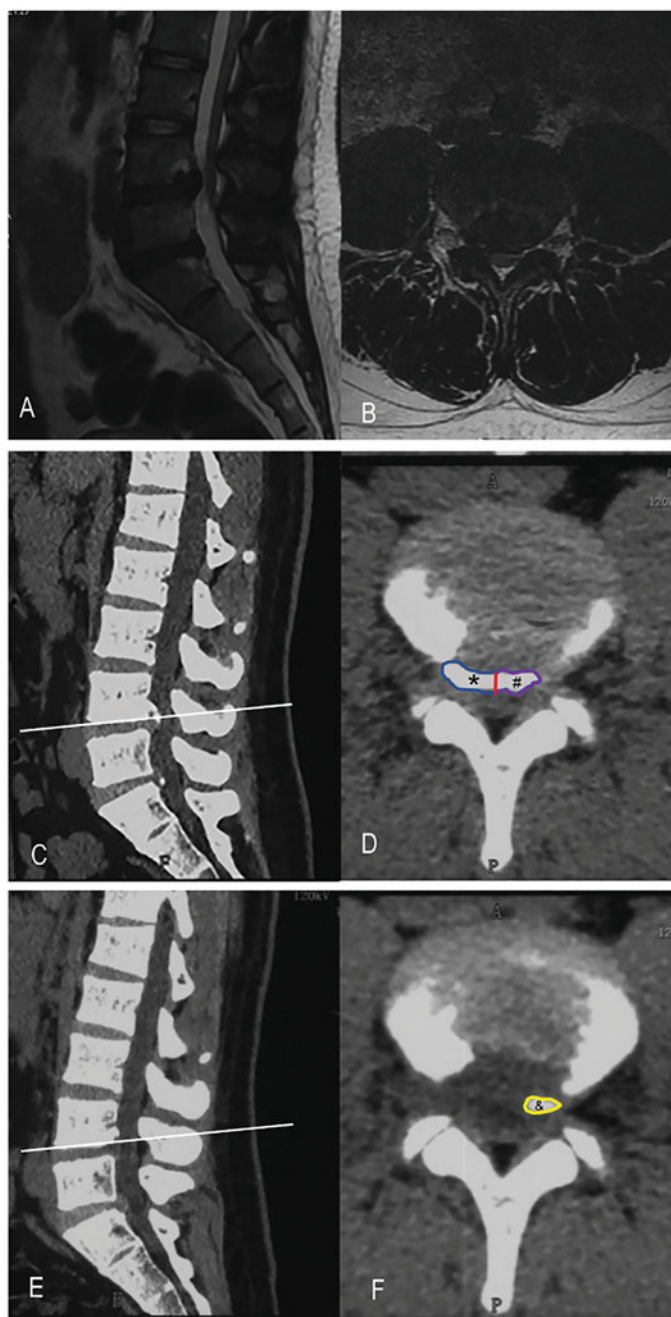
A 23-year-old man with low back pain which radiated to right lower limb since more than 6 months. Preoperative MRI and CT show calcification of L4/5 herniated intervertebral disc which has compressed the right nerve root (A, B, C, and D). CT obtained 3 months after surgery showed efficient decompression of the nerve root and successful removal of the calcified lesion (E and F). *Calcification at symptomatic side. #Calcification at contralateral. #Residual calcification.
